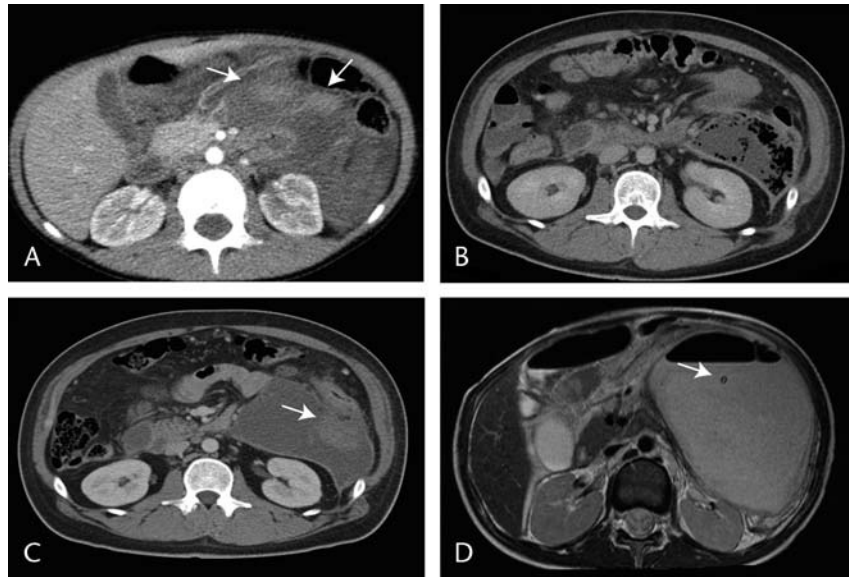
A and B show ceCT scans in a patient with AP 5 weeks before (A) with irregular cyst and probable solid debris (arrows) and (B) after the first necrosectomy and diagnosed WON, the solid material being huge necrosis. C and D show a ceCT scan (C) in a young patient after traumatic AP some weeks before again with irregular cyst and solid material (arrow); however, the same patient after T2-weighted MRI scan was done (D) after placement of a drainage shows no solid material. The patient was misdiagnosed as having WON. Treatment was successful after stent placement.
